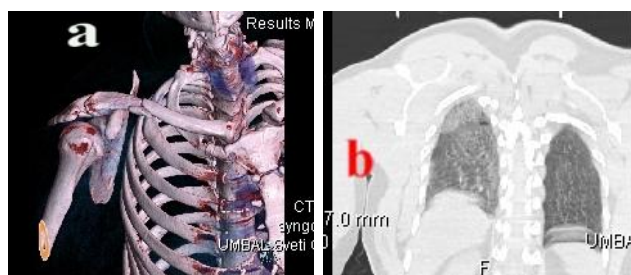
Patient 9: a - 3D computed tomography reconstruction (anterior view) showing fractures of the right clavicular and the first rib; b – sagittal computed tomography showing right pneumothorax and lung contusion
